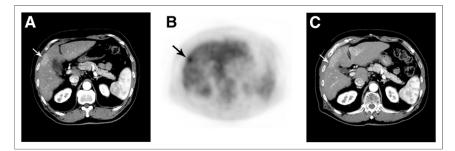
Pretreatment enhanced CT scan (A), PET scan (B), and 7 mo posttreatment enhanced CT scan (C) of tumor (arrow) that was positive on visual PET and had a T_{SUVmax} of 4.3, T_{SUVmax}/L_{SUVmax} of 1.23, and CT/¹⁸F-FDG PET score of 6. Patient underwent SABR of 45 Gy in 5 fractions. Tumor recurred at 7 mo after SABR.
